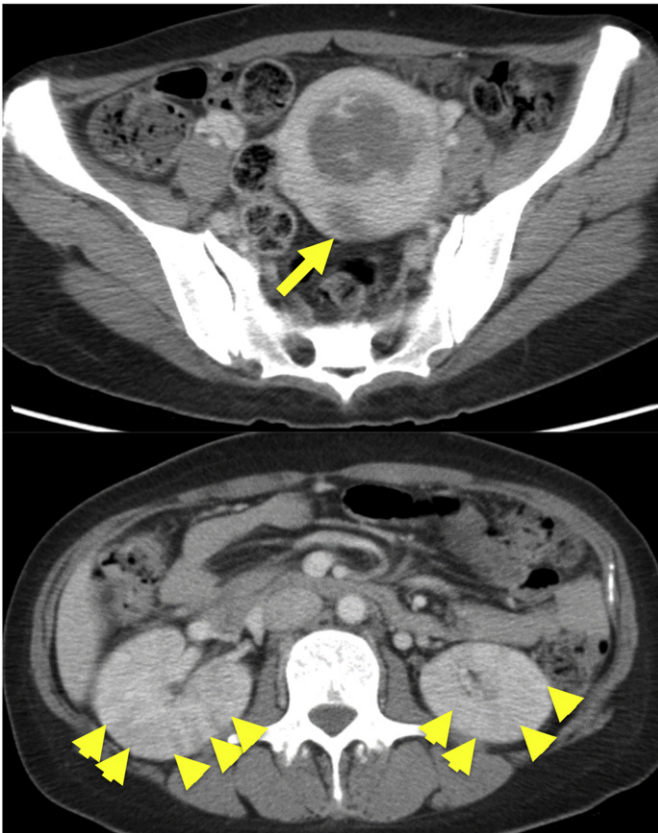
Pelvic computed tomography (CT) scan (upper panel) showed low density area in the posterior wall of uterine corpus, indicating the uterine abscess (arrow). Abdominal CT scan (lower panel) revealed multiple low density areas in bilateral kidneys, indicating renal infarctions (arrow heads).
